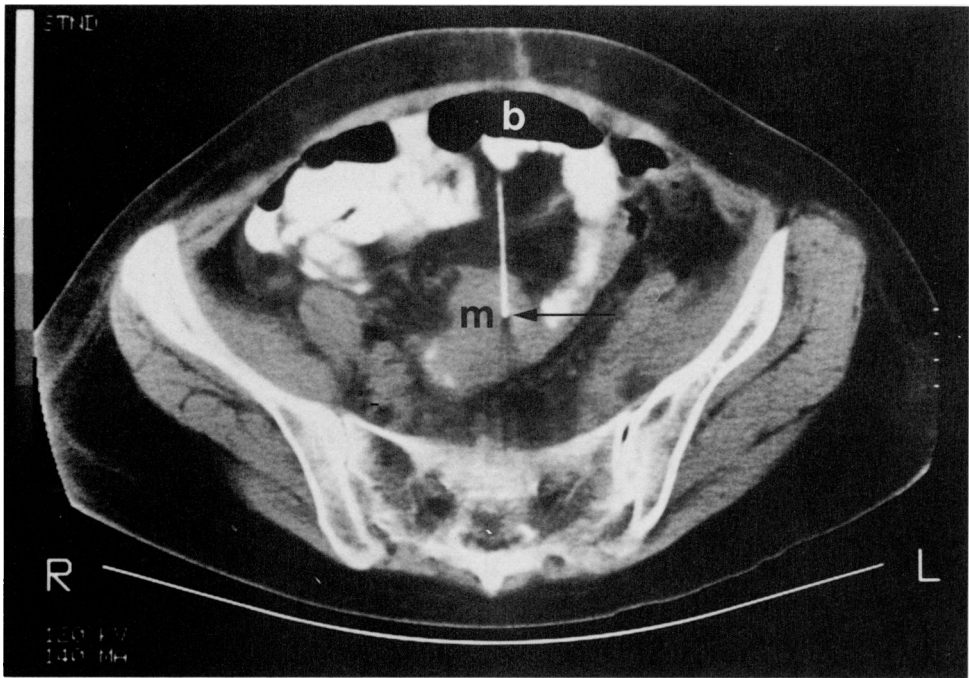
CT scan of PFNAB of bowel mass (m) in patient with known ovarian primary revealing metastatic disease. Note that bowel (b) is freely transgressed. Arrow indicates needle tip.
